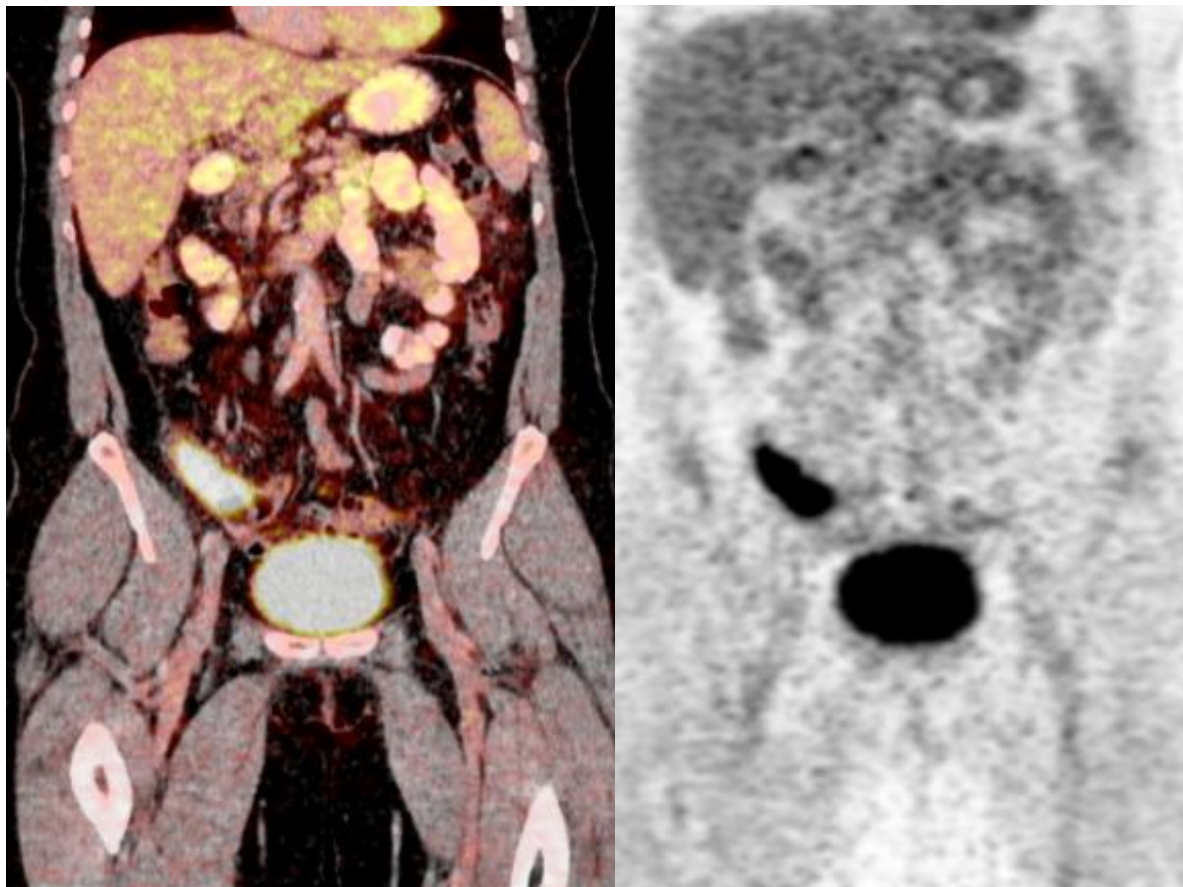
Coronal images from PET CT. Markedly abnormal FDG activity (SUV max 31) within the appendix and caecum
